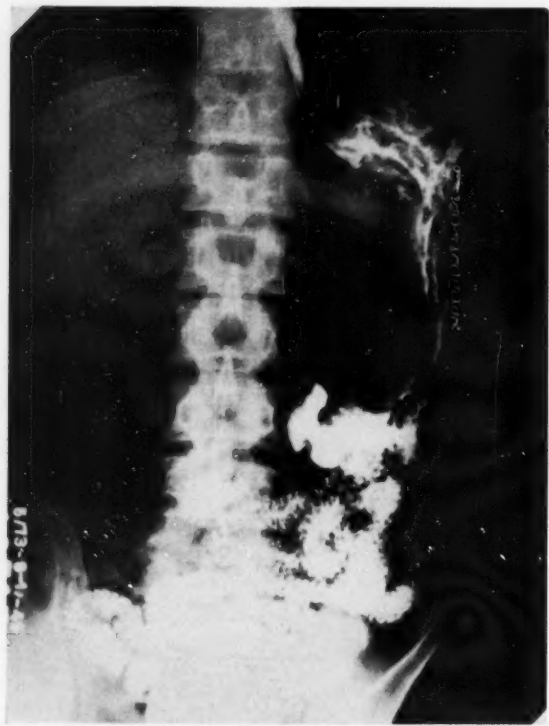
Gastrointestinal x-ray of Case 4 (S. D.) showing "J" shaped outline of stomach apparently compressed to the left by an extrinsic mass.
